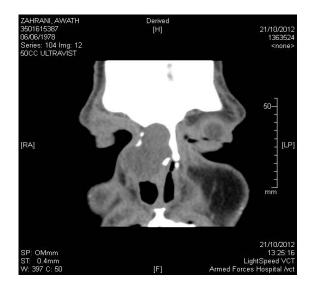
CT scan of PNS viewing the ethmoid mucoecle in the right side.
